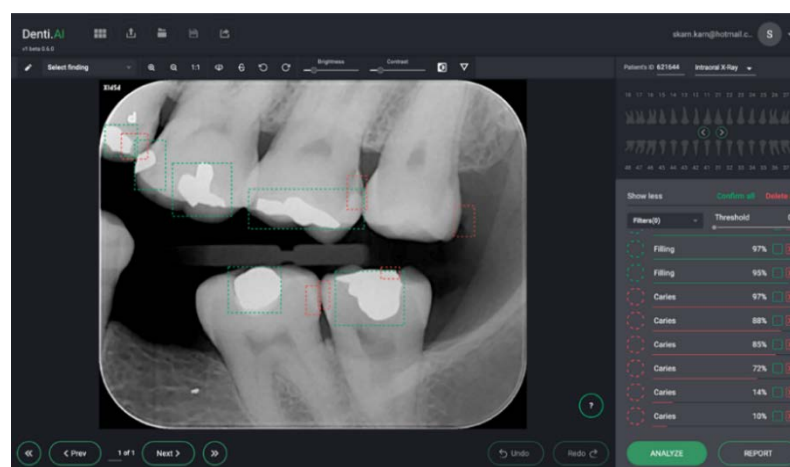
Diagnostic results shown on the radiograph
